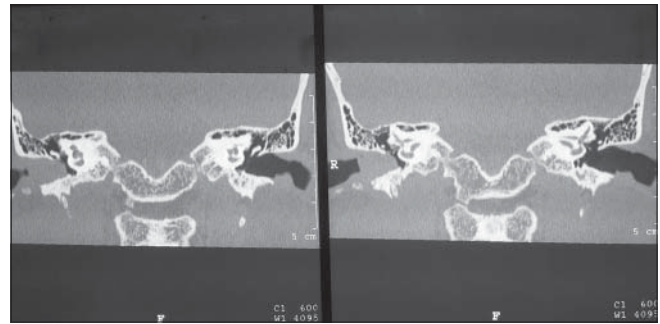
Coronal cut of contrast enhanced computed tomography scan showing right basal cell malignancy with erosion of floor of external auditory canal. The middle ear cavity on right side appears normal
